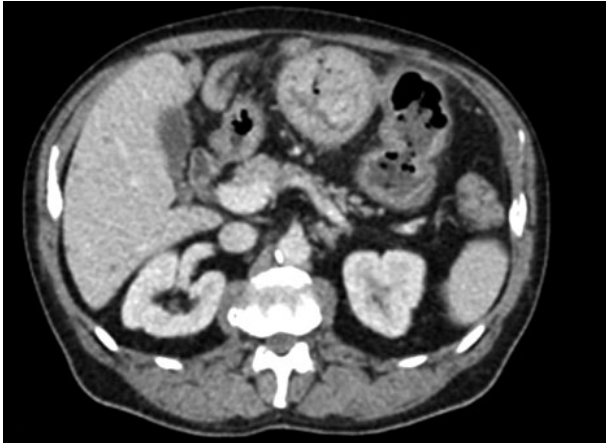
CT-scan showing a 9 cm subocclusive tumor located at the previous anastomosis.
